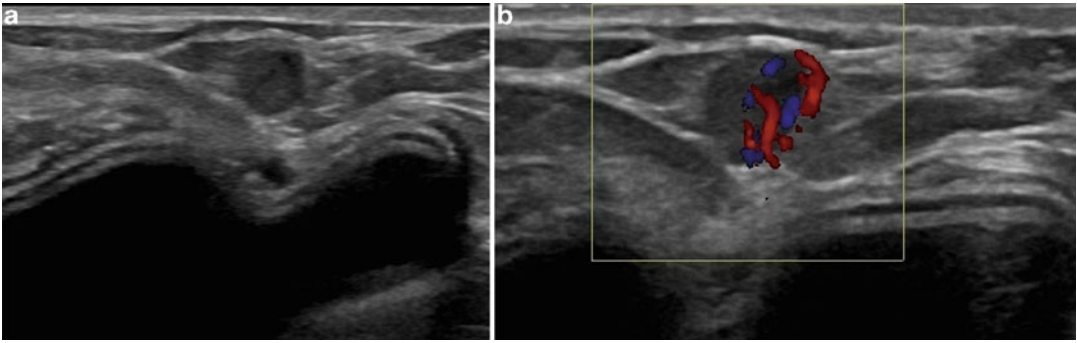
Color Doppler imaging. (a) Solid palpable round mass with indeterminate morphological features in a patient with an implant. (b) Color Doppler imaging
